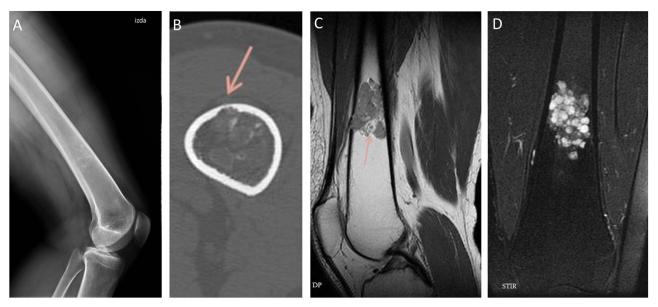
A. 42-year-old woman in study due to a painless lesion in the distal femur. Plain radiograph (A) and CT (B) show a chondral matrix lesion in distal femur with cortical scalloping (arrow in B). These findings are also present on MR, which shows a lesion with popcorn calcifications, intermediate signal on PD (C) and high signal on STIR (D). The result of the biopsy was an enchondroma (not shown). (Color version of figure is available online.)
